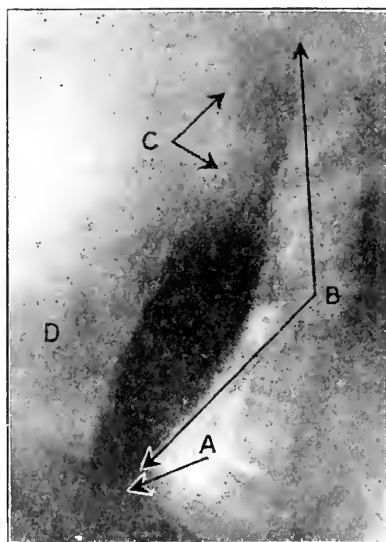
Lateral roentgenogram, showing bismuth meal retention in case of “cardiospasm.” A, closed cardia, without malformation; B, diffusely dilated esophagus, normal contour maintained; C, anterior depression caused by aortic arch; D, shadow of heart. (Roentgenogram by Joseph Johnson.)
